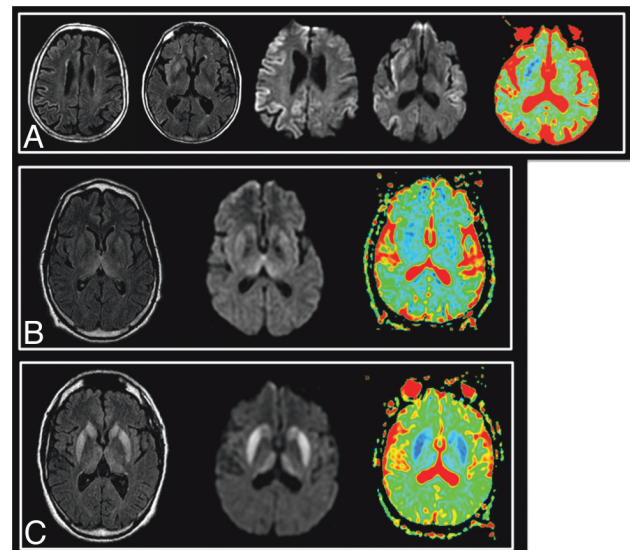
Typical images in cases of sCJD (A), vCJD (B), and gCJD (C). FLAIR, DWI, and ADC map, respectively, are shown. Areas of increased signal intensity, which involve the cortex and the striatum are more extensive and more clearly visible on diffusion images. On the basal ganglia, these changes are associated with a decreased ADC. There is widespread involvement of the cortex in the patient with sCJD. gCJD and vCJD both present with lesions of the thalamus and lenticular nuclei. However, in the variant case, as opposed to the genetic one, the areas of high signal intensity are more pronounced in the pulvinar than in the striatum as has been previously described in this phenotype.
